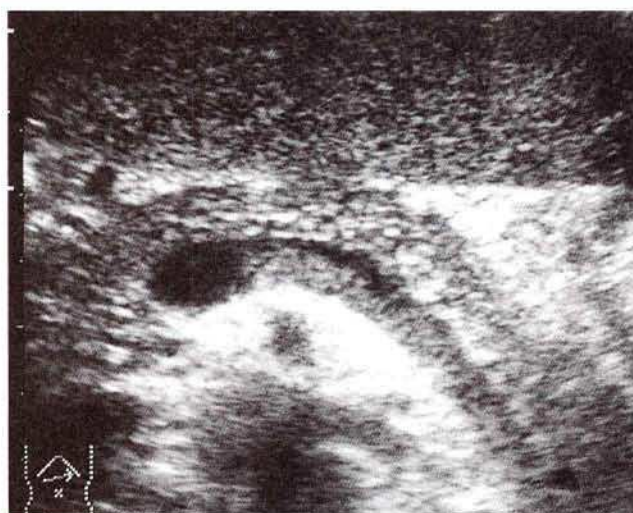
A linear hyperechoic shadow is seen along the splenic vein on ultrasonography.
